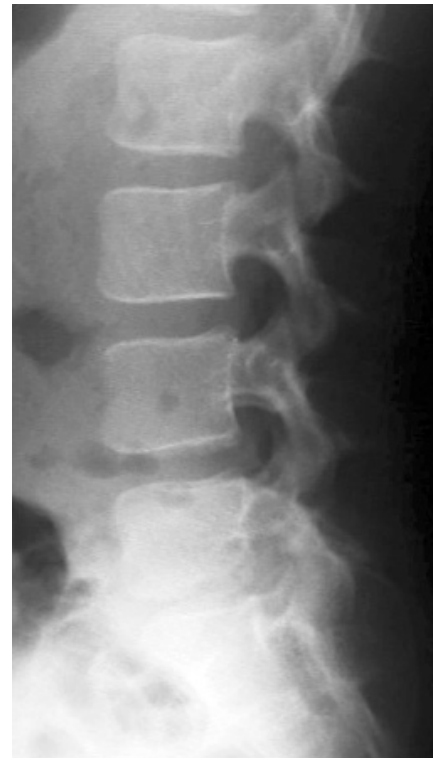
Plain radiograph showing no clear fracture fragment
